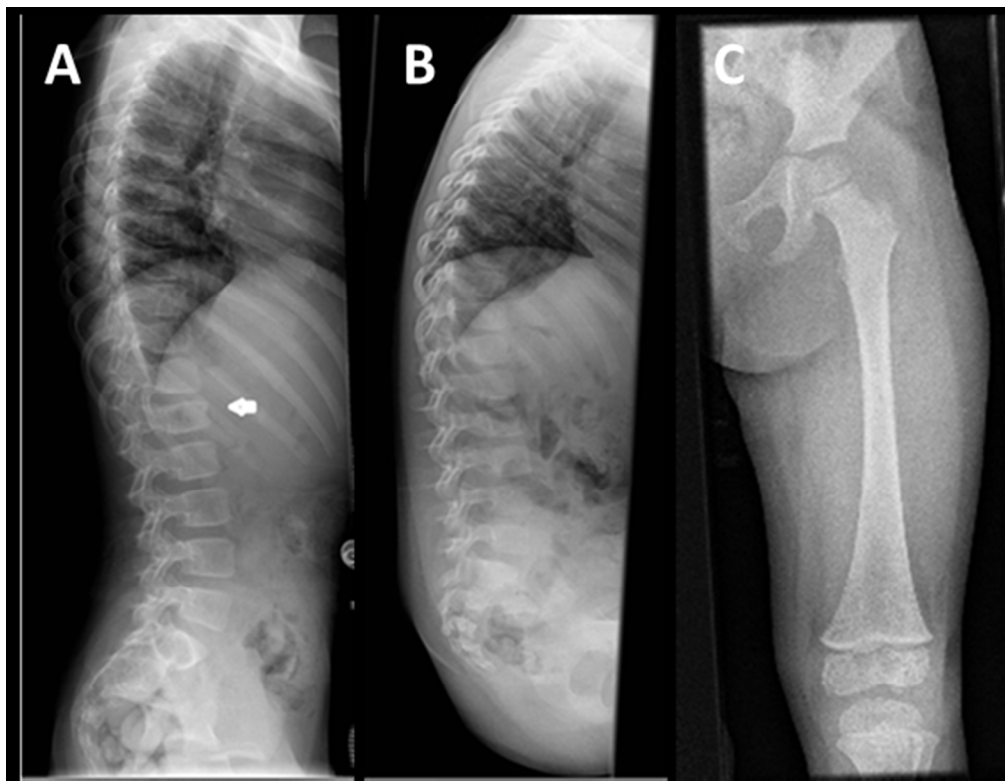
Patient 1 X-rays A. Lateral spine showing compression fracture at L1 B. Patient 2 Normal lateral spine and C. left femur
